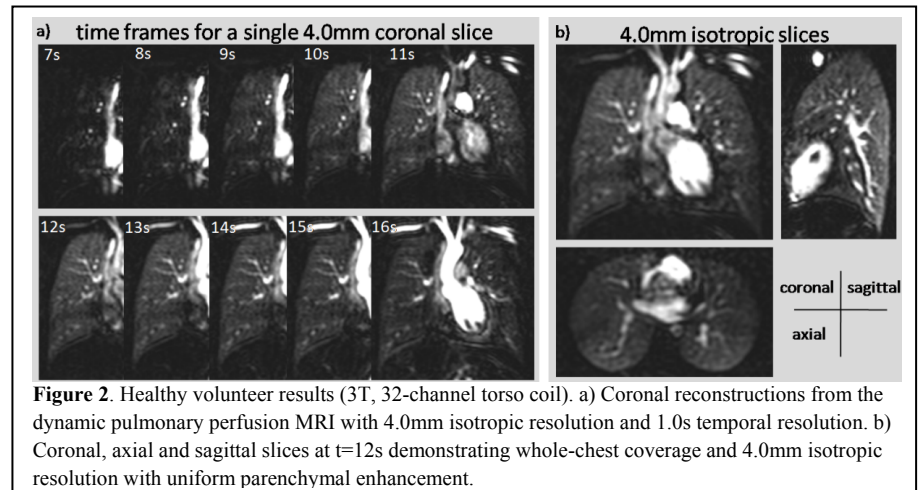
Healthy volunteer results (3T, 32-channel torso coil). a) Coronal reconstructions from the dynamic pulmonary perfusion MRI with 4.0mm isotropic resolution and 1.0s temporal resolution. b) Coronal, axial and sagittal slices at $t=12\text{s}$ demonstrating whole-chest coverage and 4.0mm isotropic resolution with uniform parenchymal enhancement.
